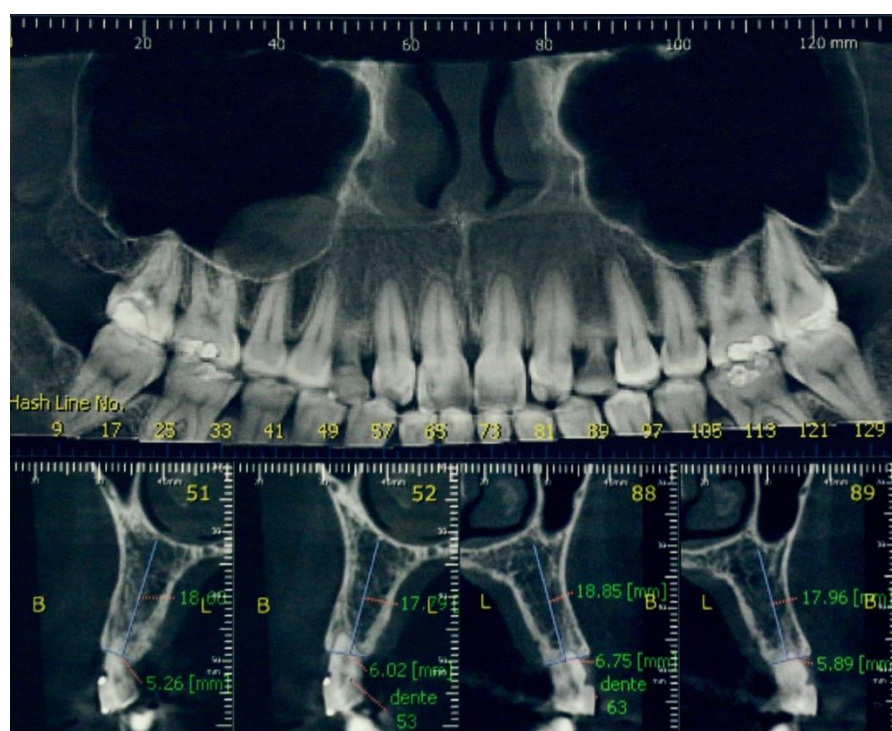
Cone beam tomography.
